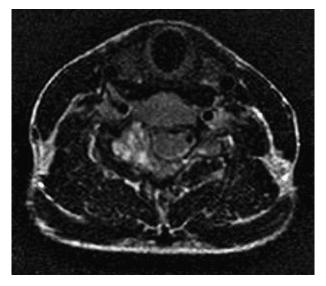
T2-weighted sagittal magnetic resonance imaging demonstrating a hyperintense lesion involving the lamina and right lateral mass of C6 extending into the neural foramen.
